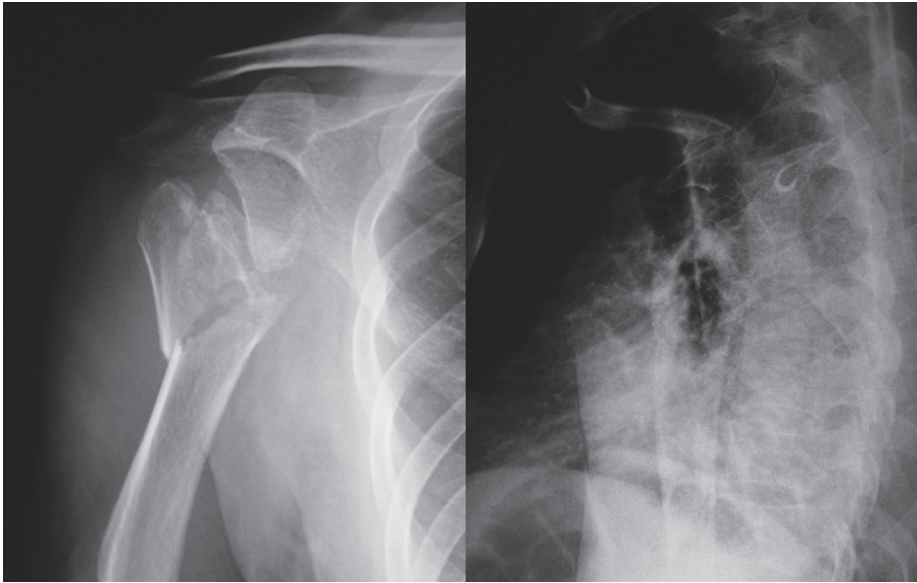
Anteroposterior and lateral position radiographs showing a displaced 3-part fracture of the proximal humerus involving the surgical neck and greater tuberosity
